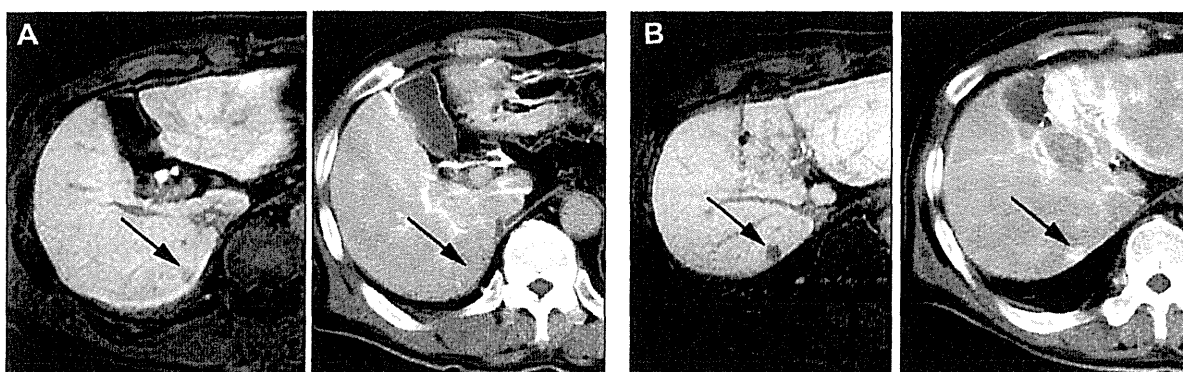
Development of multicentric hepatocellular carcinoma in patients with preoperative non-hypervascular hypointense hepatic nodules detected during the hepatobiliary phase of Gd-EOB-DTPA-enhanced MRI. (A) Hepatobiliary phase of Gd-EOB-DTPA-enhanced MRI (left panel) and computed tomography during hepatic arteriography (CTHA, right panel) before hepatectomy for hepatocellular carcinoma (HCC). In addition to the typical HCC located in segment VIII, a hypointense hepatic nodule was detected in segment VI during the hepatobiliary phase of Gd-EOB-DTPA-enhanced MRI (arrow). No hypervascular nodule was detected at this site by CTHA (arrow). (B) Hepatobiliary phase of Gd-EOB-DTPA-enhanced MRI (left panel) and CTHA (right panel) 10 months after hepatectomy for HCC. The nodule detected during the hepatobiliary phase of Gd-EOB-DTPA-enhanced MRI showed minute growth in size, with clearer margin, compared to preoperative image (arrow). The hypervascularity of this nodule was identified by CTHA (arrow). This nodule was resected by re-hepatectomy and was diagnosed as HCC pathologically.
